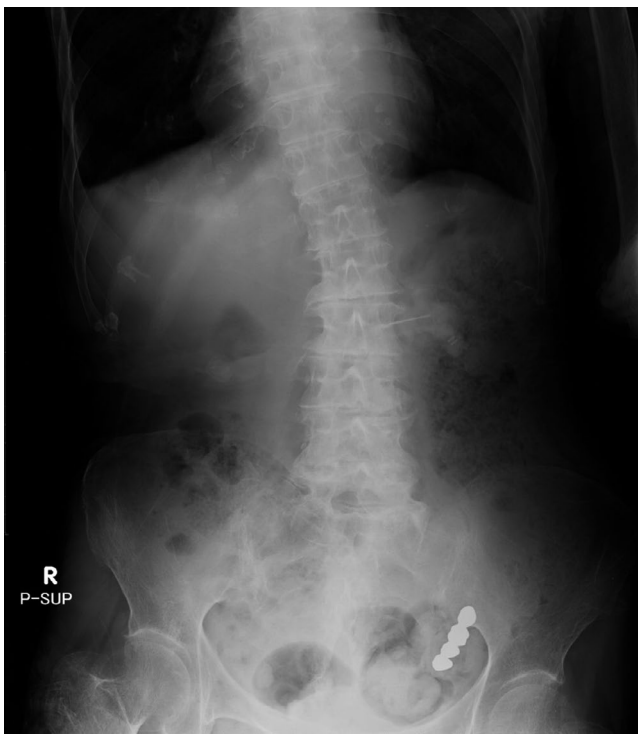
Abdominal X-ray showing the dental crown at left lower quadrant of the abdomen on day 5
